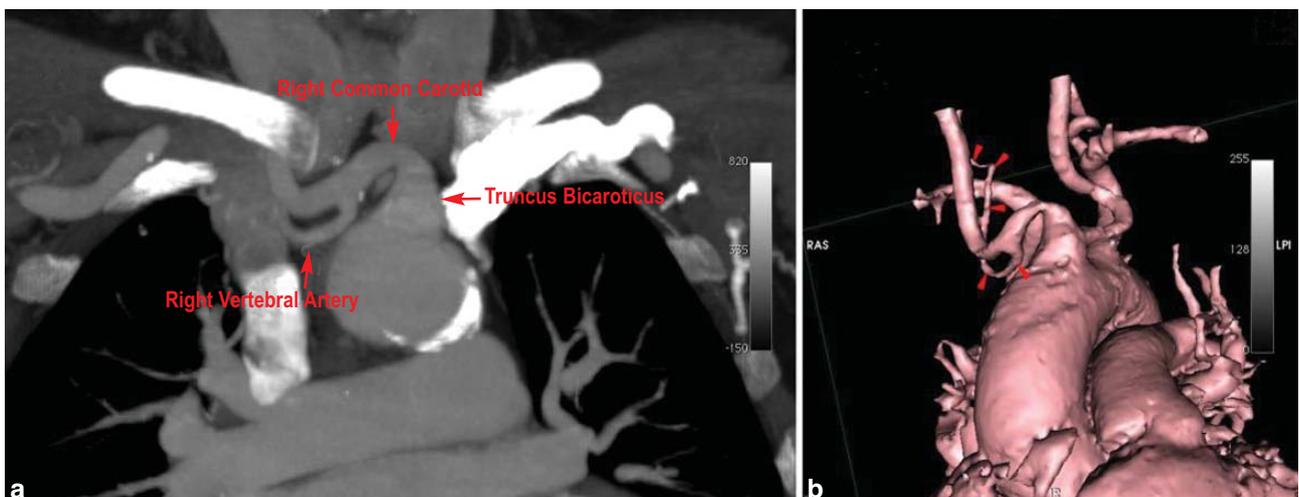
Chest CT reconstruction showing the aberrant origin of the right vertebral artery from the right common carotid. (a: Thick slab planar reconstruction b: 3D reconstruction).
